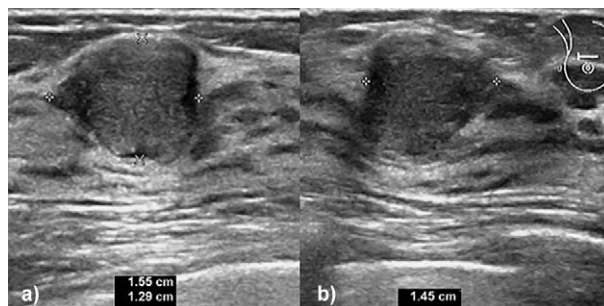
Ultrasonography (linear transducer with a frequency of 3–14 MHz) of a mass in 10 o'clock position in the right breast shows a hypoechoic irregular mass. The breast tumor size was measured in three dimensions: a) two major axes perpendicular to each other; b) the third major axis perpendicular to the previous two.
